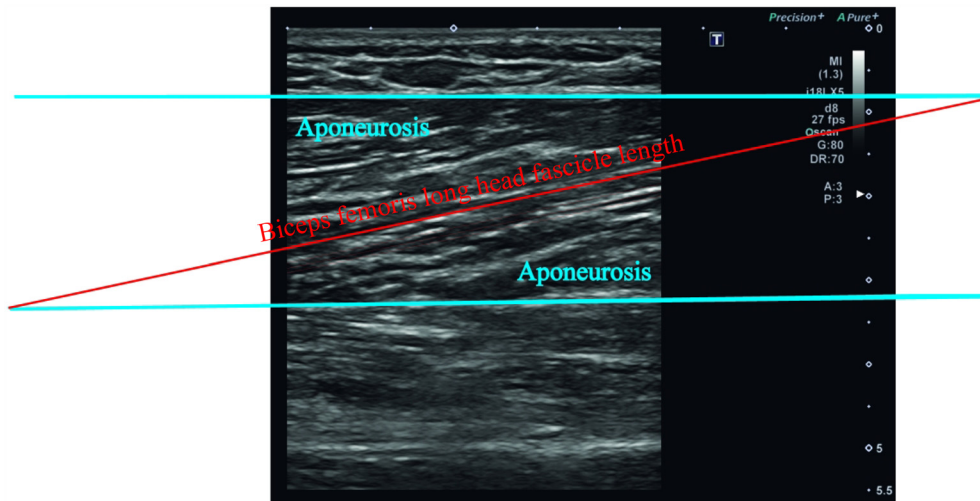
Example of biceps femoris long head fascicle length measurements via B-mode ultrasound. Fascicle length was calculated based on the manual linear extrapolation method by following the methodology of a recent study.²⁴
